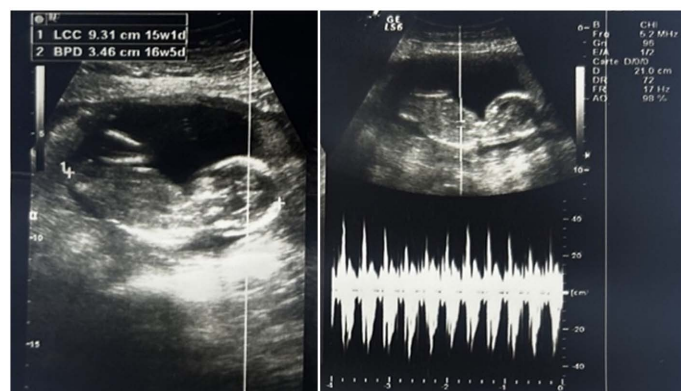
Ultrasound image of the living fetus.
